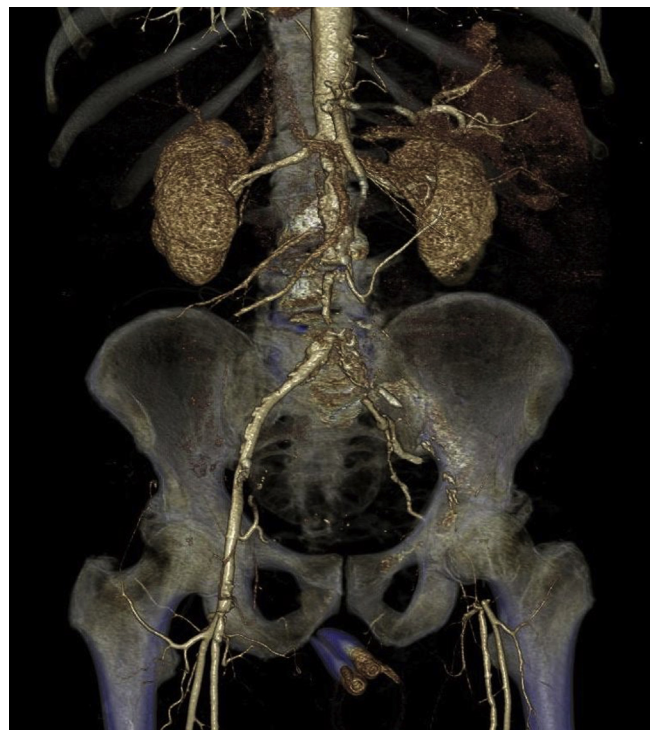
Computed tomography angiography (CTA) three-dimensional image shows occlusion of the distal abdominal aorta and the origin of both common iliac arteries, extended through the left iliac axis to the femoral bifurcation, with a patent right iliac axis.
